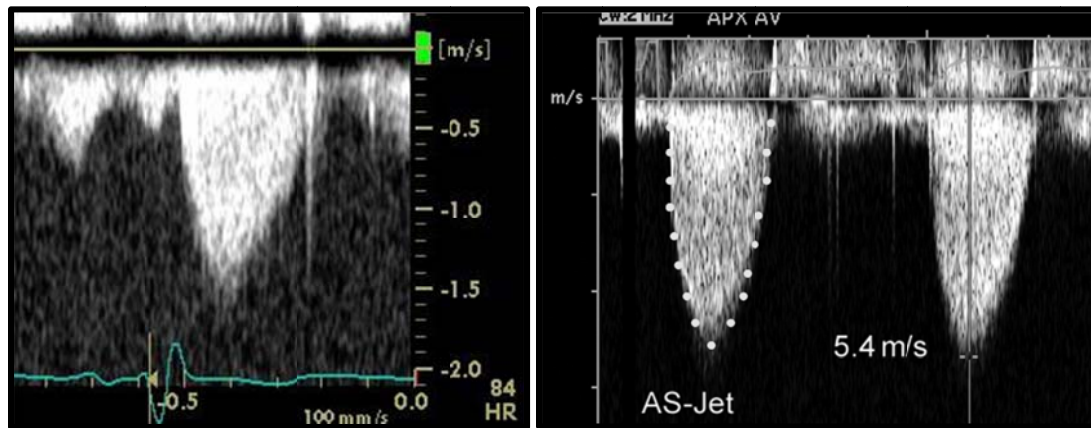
In vivo Doppler echocardiography traces from a healthy, Vmax 1.6ms, (left) and stenotic, Vmax 5.4ms, (right) aortic valve (Note the difference in scale in the y axis)
